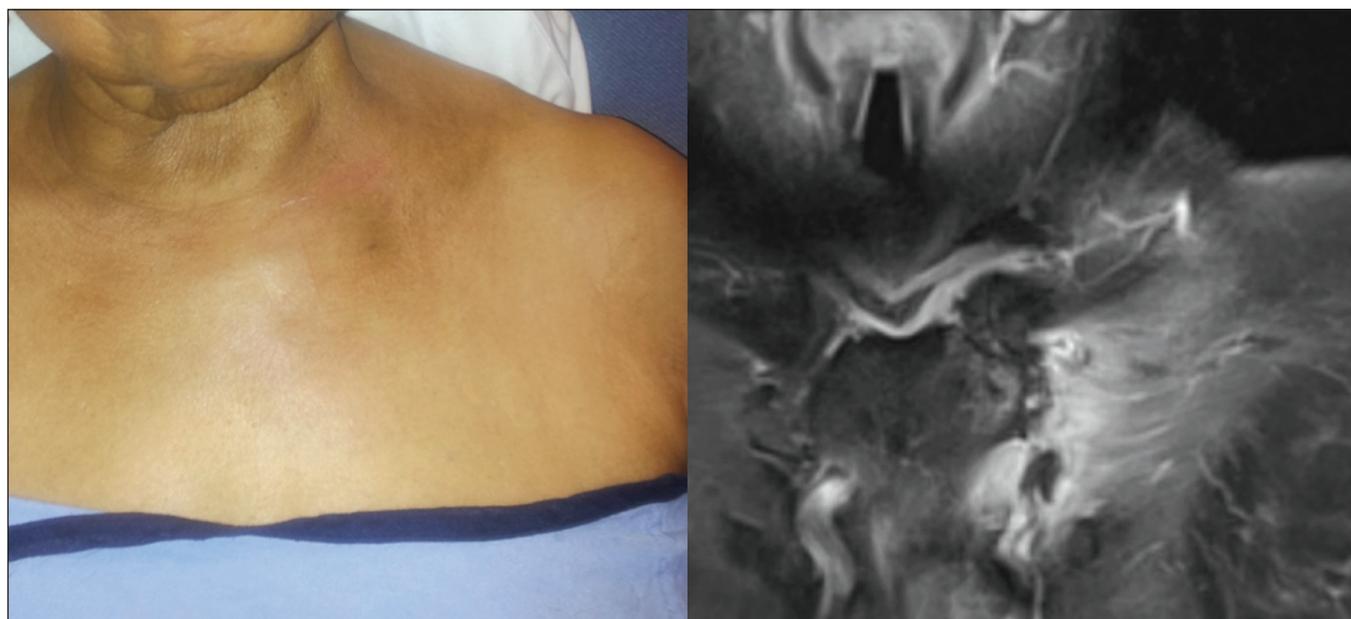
Left: physical examination findings of edema, erythema and torticollis; right: corresponding magnetic resonance image displaying soft tissue and manubrium signal uptake, as well as joint space effusion
